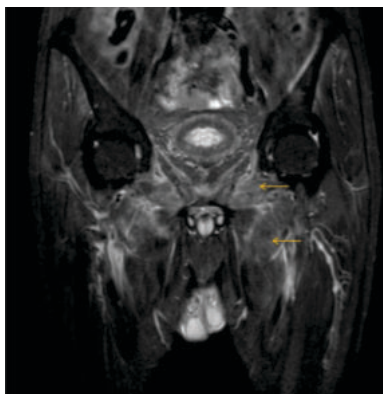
MRI T2 fat saturation coronal section edema of the bilateral obturator externus and adductor muscle.
